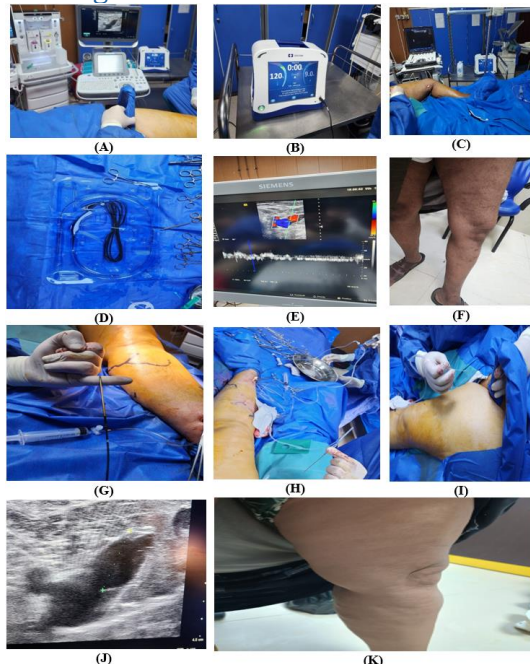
(A): Intraoperative ultrasound-guided localization of the saphenofemoral junction, (B):
